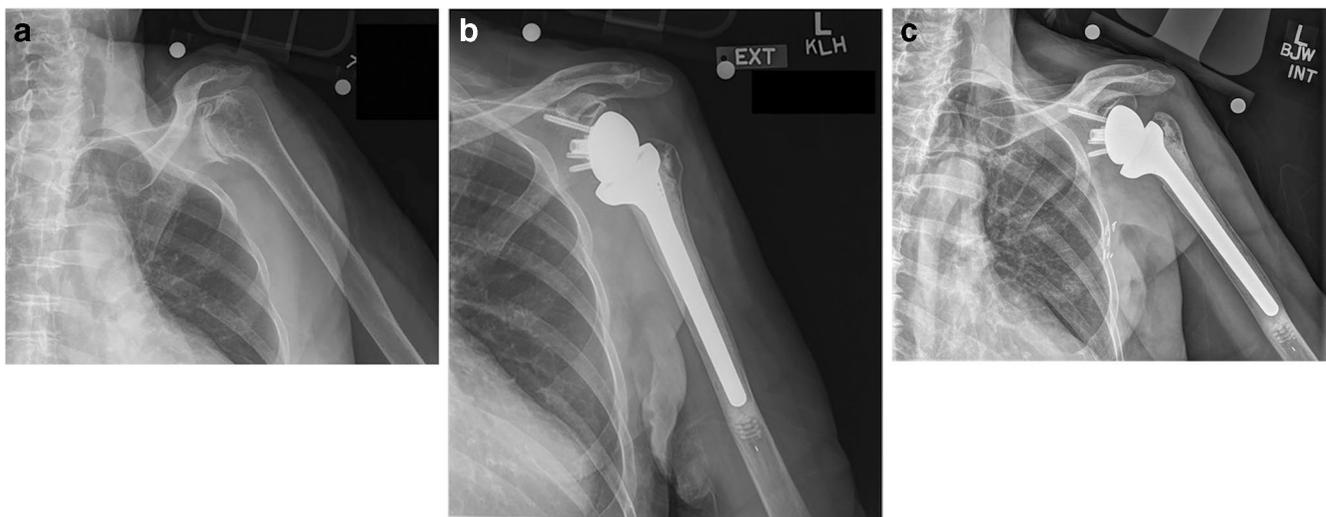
Case example: a Preoperative, b Initial post-operative, and c Final follow up (72 months post-surgery) x-rays of a 68-year female treated with a reverse shoulder arthroplasty using a cemented humeral stem with excellent radiographic and clinical outcome
